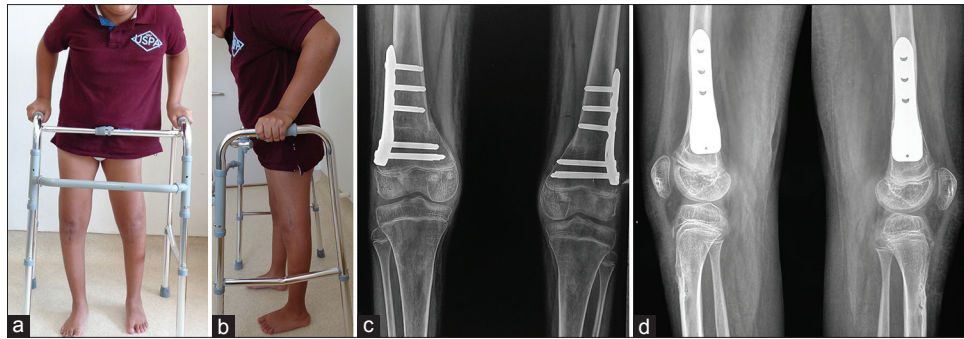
Clinical and radiological result in a 13-year-old boy (gross motor functional classification system Level IV) who underwent distal femoral extension osteotomy + patellar tendon advancement by the described technique. (a) Postoperative clinical photograph showing normal alignment in the anteroposterior view. (b) Postoperative clinical photograph showing complete correction of knee flexion deformity in the lateral view. (c) Anteroposterior radiograph of both knees showing fixation of the distal femoral extension osteotomy with 90° pediatric condylar locking compression plate. (d) Lateral radiograph of both knees showing complete correction of knee flexion deformity and patella alta
